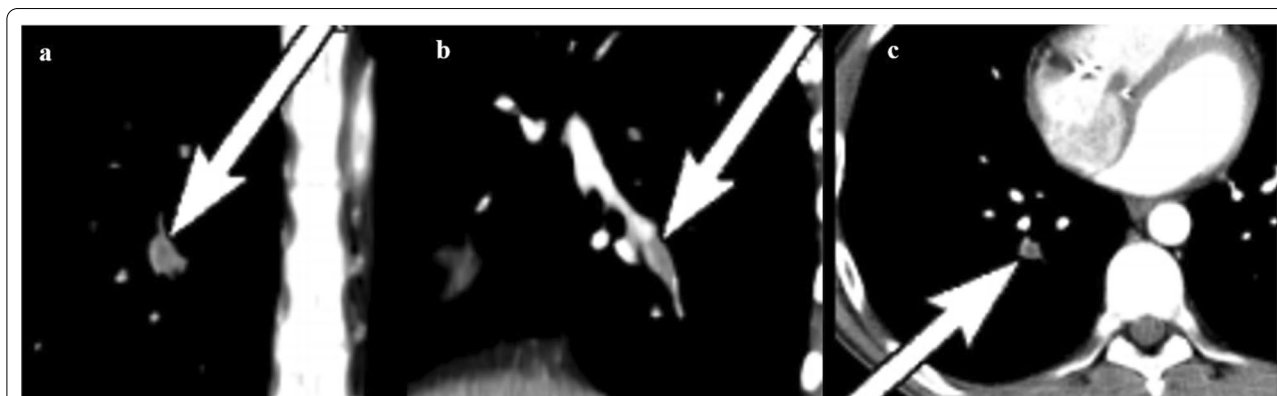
CT pulmonary angiography revealed filling defects (arrow) of pulmonary artery branch supplying right lower lobe, consistent with pulmonary emboli (a:sagittal plane, b:coronary plane, c:axial plane)
